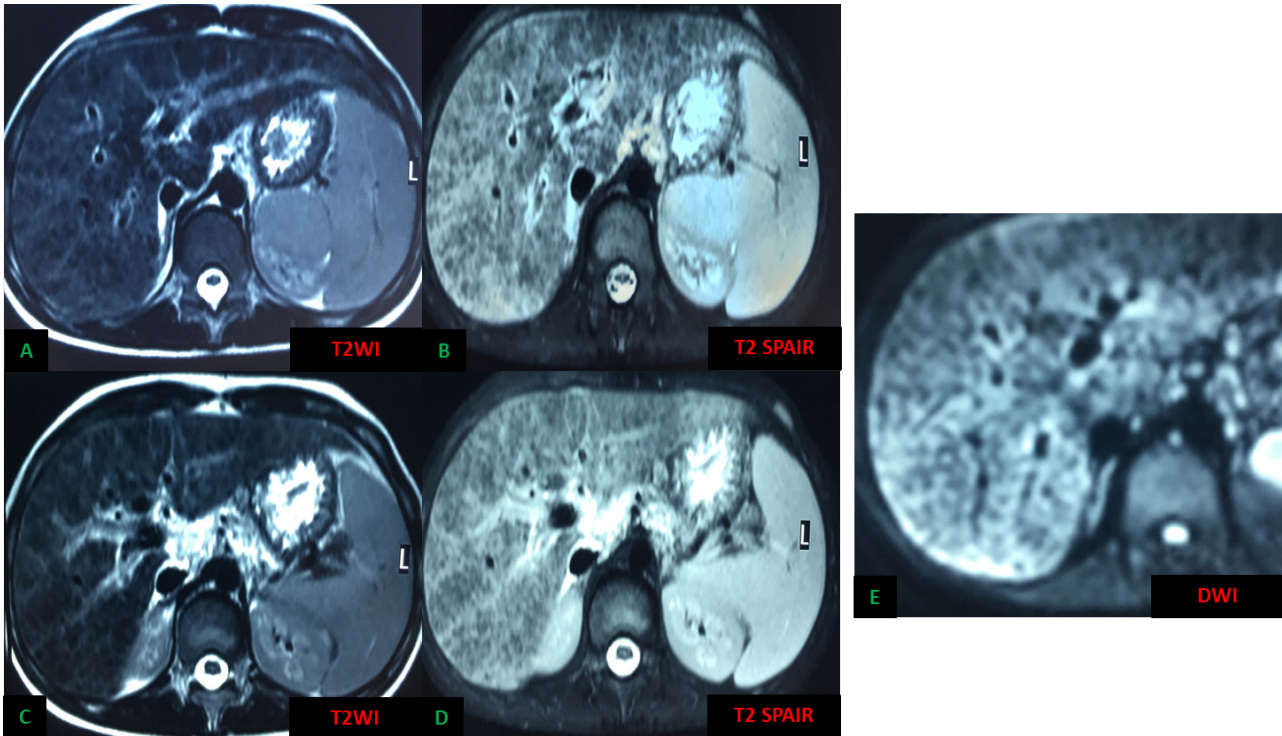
Bridging fibrosis in a 13-year-old patient with autoimmune hepatitis. Reticular hyperintensity throughout the liver parenchyma on T2WI (A, C), fat-saturated T2WI (B, D) and DWI (E).
